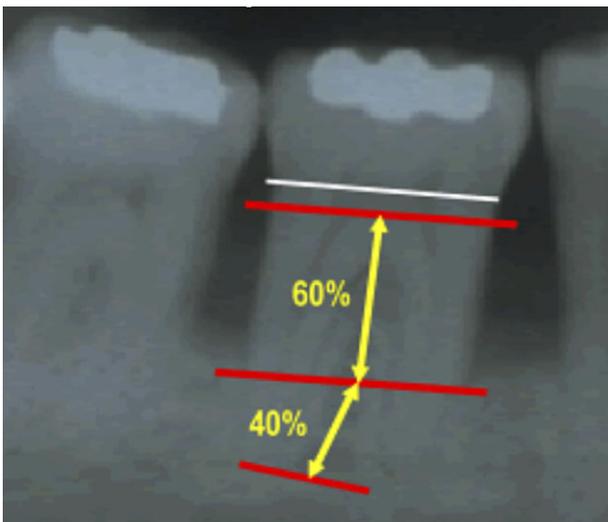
A molar with approximately 60% attachment loss, evaluated on a radiograph. This tooth would be considered to be doubtful if presented in an individual younger than 60 yr of age.
